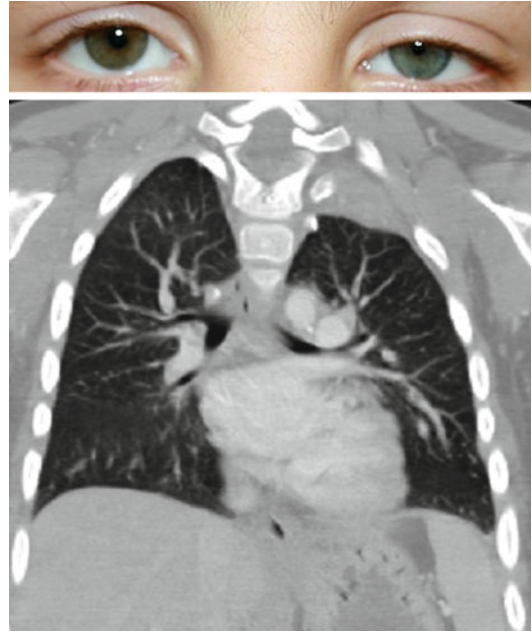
(a) A young boy presented with a history of congenital Horner syndrome; note ptosis of the left upper eyelid, ptosis of the left lower eyelid, miosis of the left pupil, and iris heterochromia with the affected pupil lighter than the unaffected pupil. (b) CT chest showed a left apical neuroblastoma (Figure courtesy of Gena Heidary, M.D)
